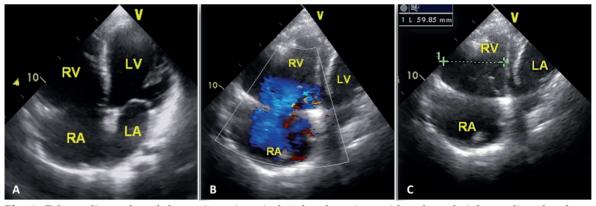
Echocardiography of the patient: A: apical 4-chamber view with enlarged right cardiac chambers; B: severe tricuspid regurgitation; C: apical 4-chamber view with RV dimension.
